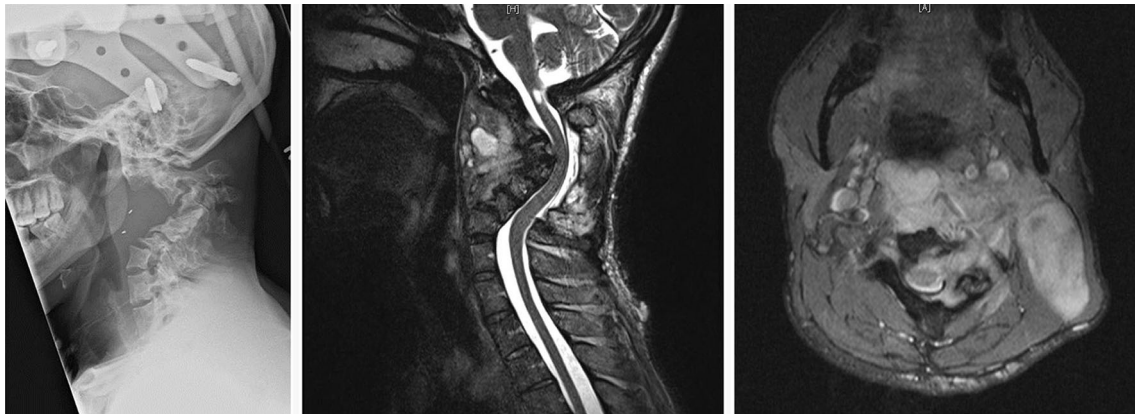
Pre-operative radiograph and MRI depicting cervical kyphotic deformity and remodeling of the C2–C4 vertebral bodies
